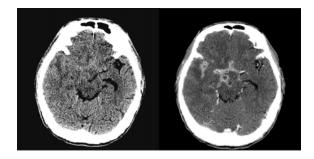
1 in 10 cases of tuberculous meningitis by CT; marked leptomeningeal enhancement at basal cistern. Final was proved by CSF culture and PCR
